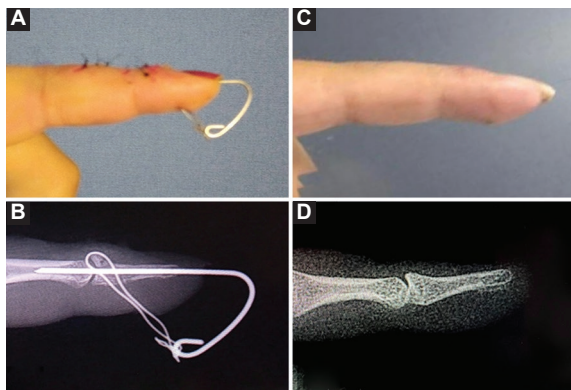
Example case of wire. A: postoperative lateral view. B: postoperative lateral radiograph. C: lateral view 15 days after removing wire and K-wire. D: radiograph follow-up.
